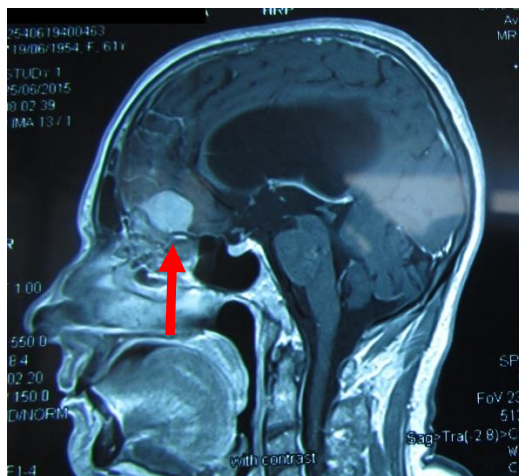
MRI: olfactory groove meningioma (Personal collection of Prof. Dr. A. V. Ciurea)
